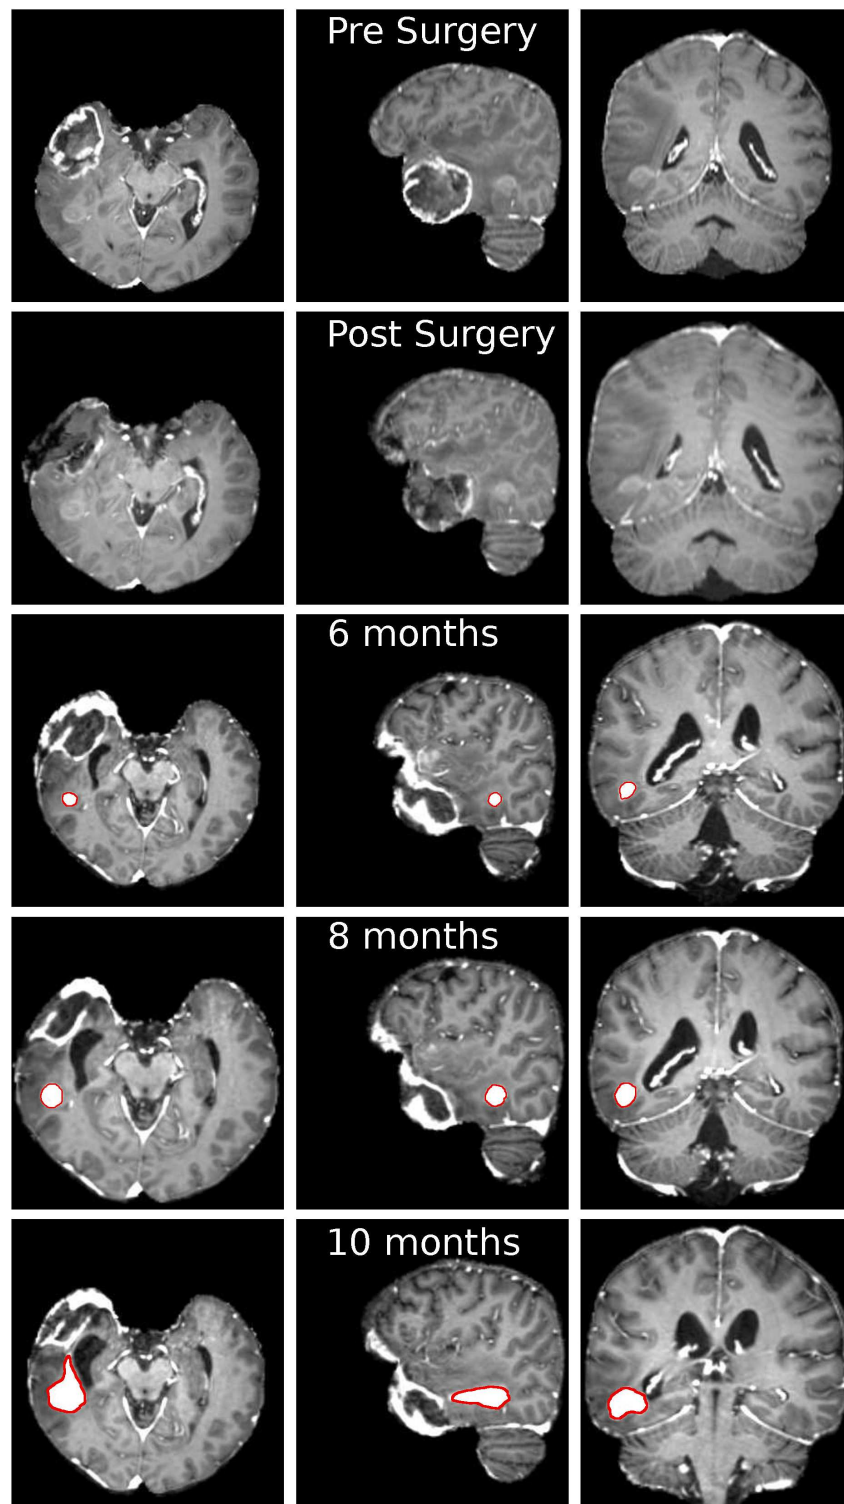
Axial (first column), sagittal (second column) and coronal (third column) slices of the T1-weighted MRI at different temporal stages. First row: before surgery; second row: after surgery; third row: 6 months after surgery; fourth row: 8 months after surgery; fifth row: 10 months after surgery. It is possible to appreciate the progressive volumetric increase of the posterior temporal mass. The segmented boundary of the tumour is highlighted in red color.
